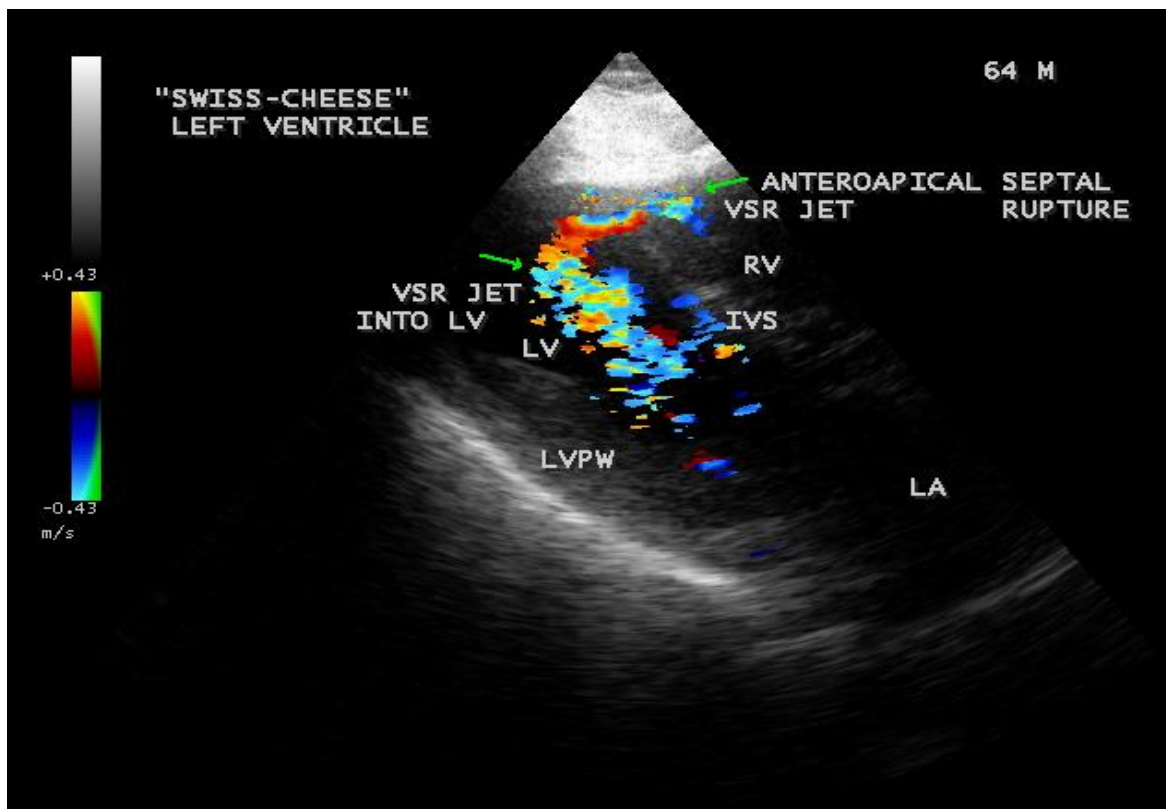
Parasternal long axis view showing the flow into the left ventricle through the septal rupture.
